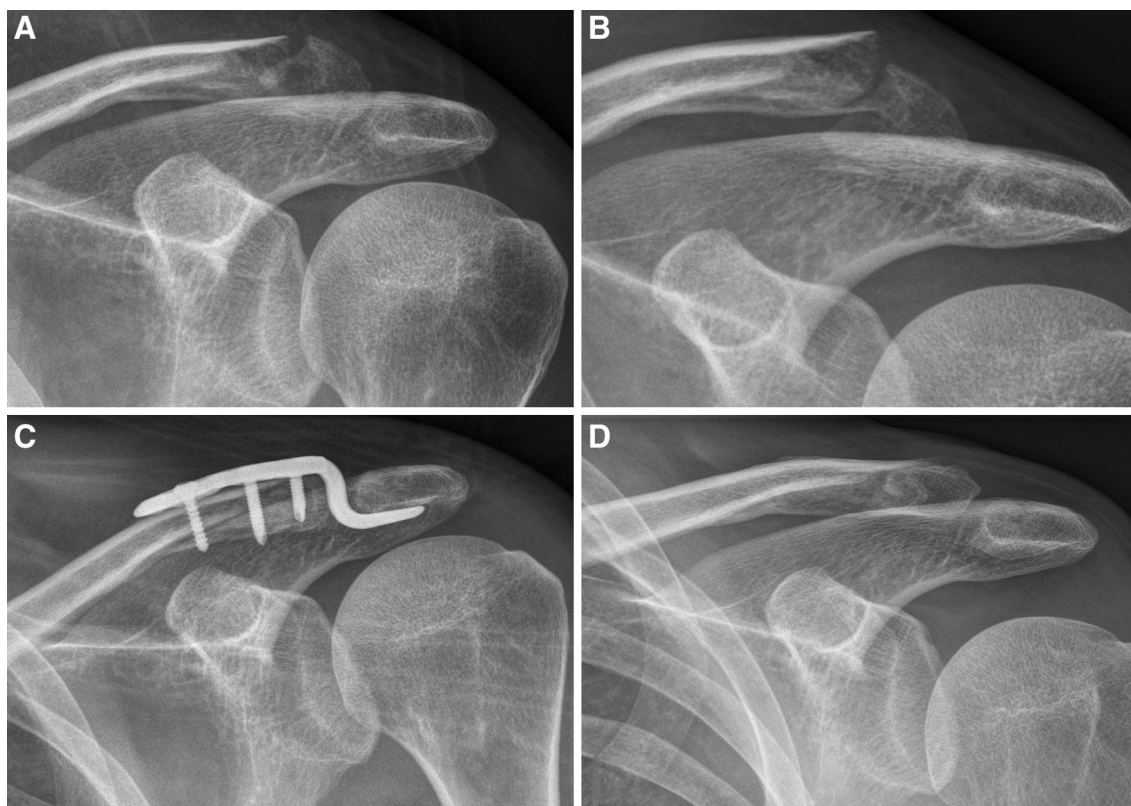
Example of HPO of a Neer IIB fracture. Anterior–posterior view without weight (a), anterior–posterior stress radiography with 10 kg vertical loading (b), anterior–posterior view of consolidated
